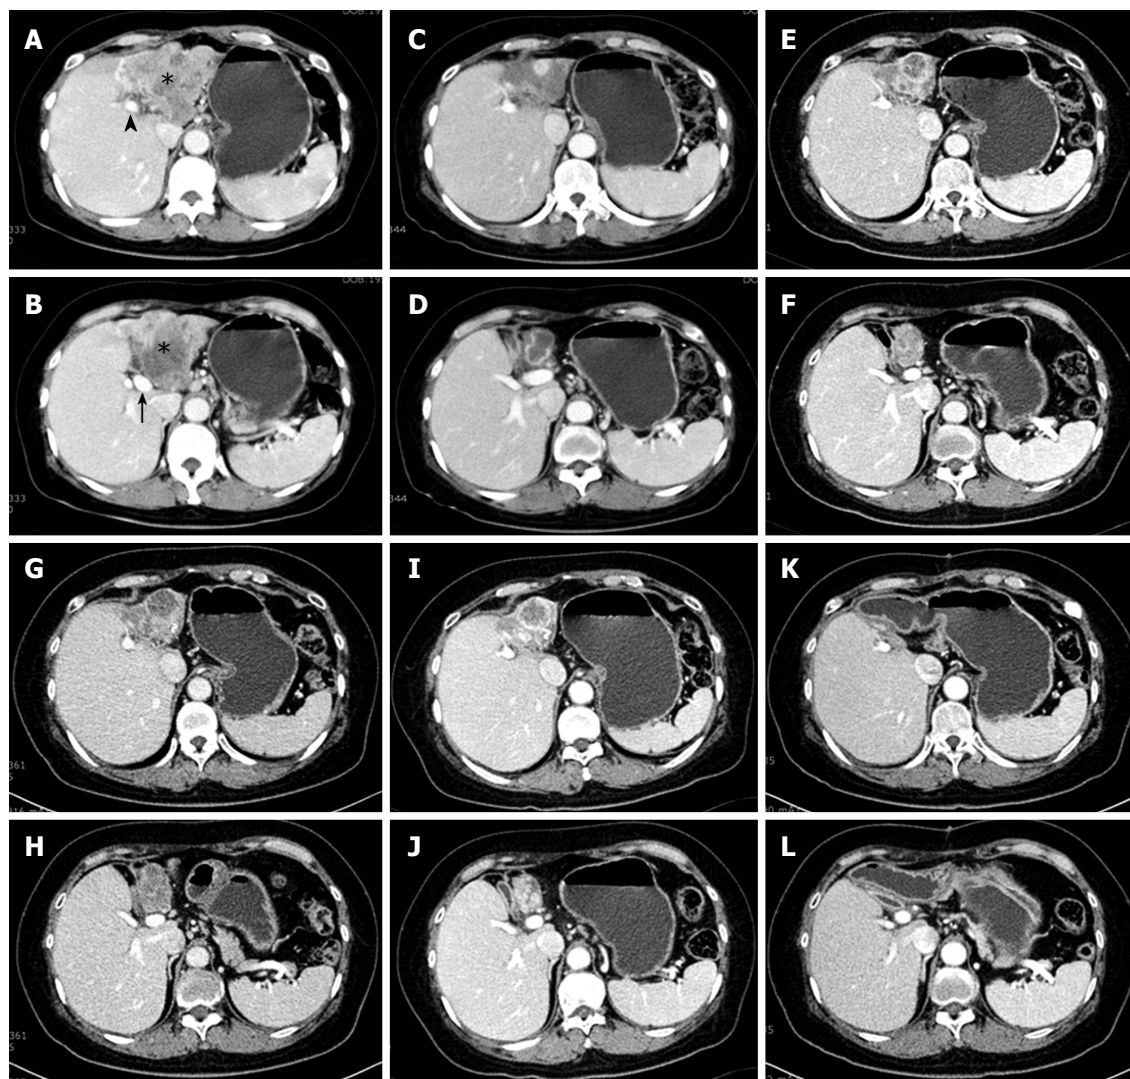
Abdominal CT scan images at two different levels are shown serially. A: At left portal vein level (black arrowhead), a 10 cm sized irregular hypovascular mass (asterisk) occupying left hepatic lobe is shown; B: At lower, main portal vein level (black arrow), the inferiorly grown mass is shown. Invasion of middle hepatic vein and left portal vein were strongly suggested with multiple lymph node enlargements at the liver hilum and lesser omentum; C and D: On CT scan taken after the end of the first 6 cycles (18 times) of gemcitabine chemotherapy, the tumor mass decreased in size dramatically, smaller than half of the previous diameter; E and F: On CT scan on 3 years and 3 mo from diagnosis, mass does not show any significant change except for a little sclerotic change; G and H: On CT scan on 4 years from diagnosis, tumor mass shows re-increment of the size than previous study; I and J: On follow up CT scan after second 5 cycles of gemcitabine chemotherapy, partial response is shown again with slight decrease of the mass size; K and L: On CT scan taken 11 months after R0 resection, there is no any recurrence or new lesion growing.
